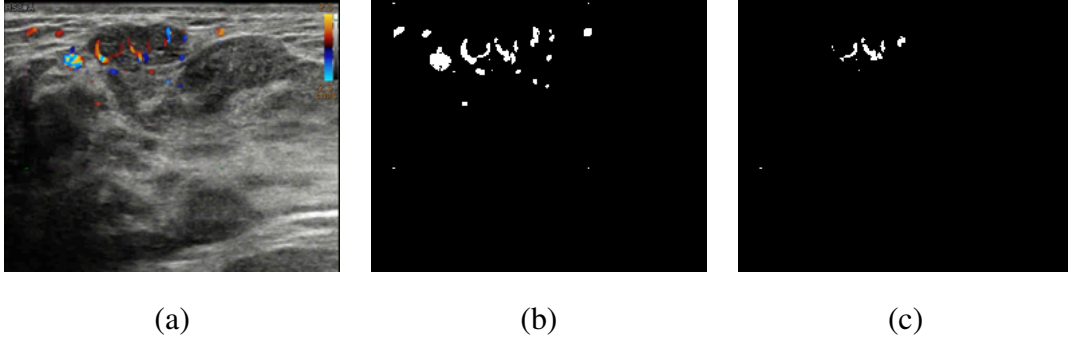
(a) Power Doppler image. (b) Binarized Power Doppler image. (c) Common area of vascular flows area and dark region area.
